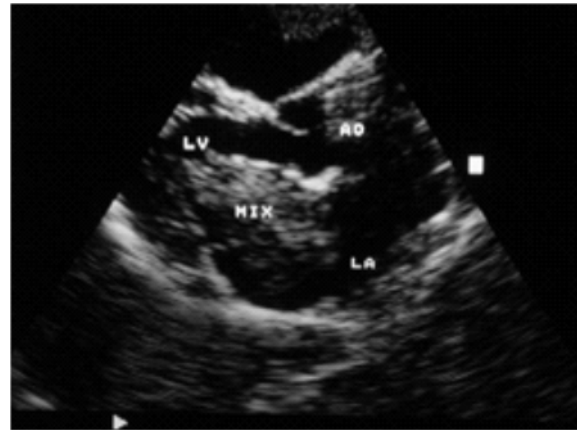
Two dimensional echocardiogram of myxoma: Note tumor plop to left ventricle during diastole and concomitant mitral insufficiency.
